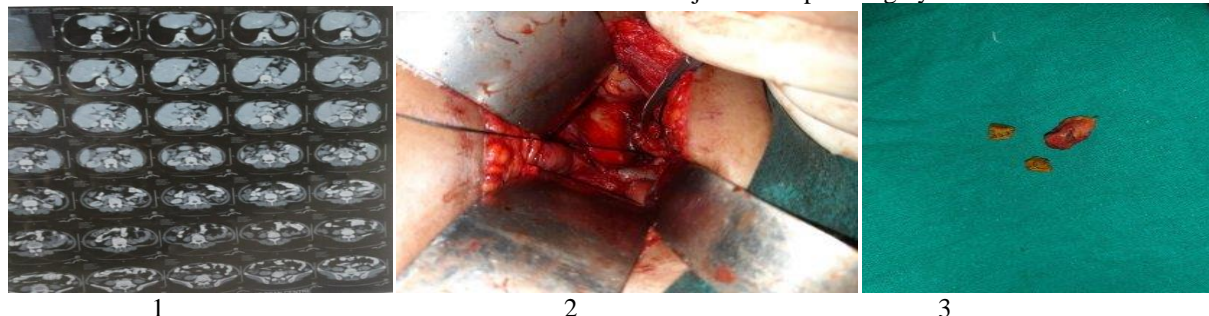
CT finding are prominent gall bladder stump with radio opaque stone
